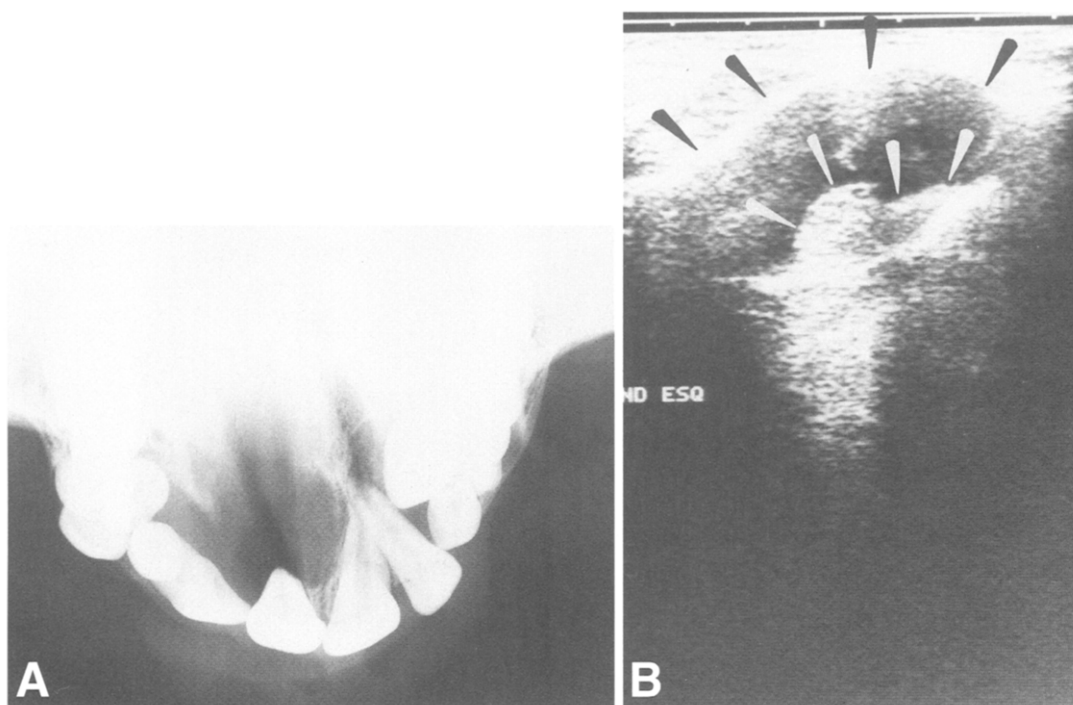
A, Occlusal radiograph of ameloblastoma of anterior right maxilla in a 33-year-old white man. Lesion shows well-defined multilocular radiolucent image causing root resorption on central incisor. B, US image of same lesion shows mixed US aspect. Hyperechoic areas (*white arrows*) correspond to solid part of tumor. Hypoechoic areas (*black arrows*) correspond to cystic part of tumor.
